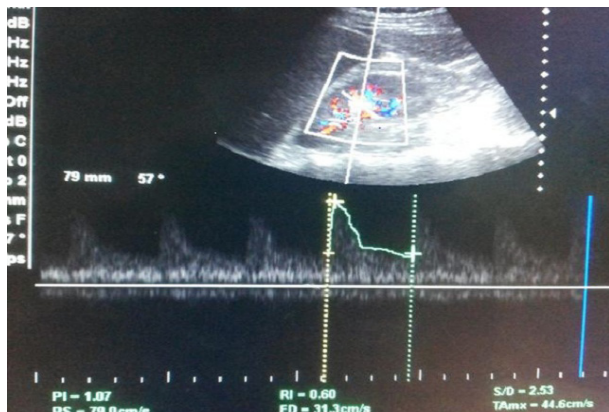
Doppler sonography showing spectral waveform with values of PSV, EDV, PI and RI in CKD stage 3 patient.
